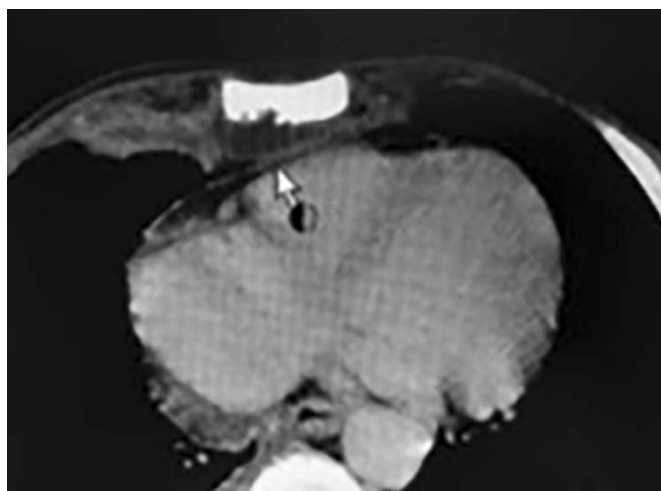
CT scan Chest with arrow pointing at fluid collection
